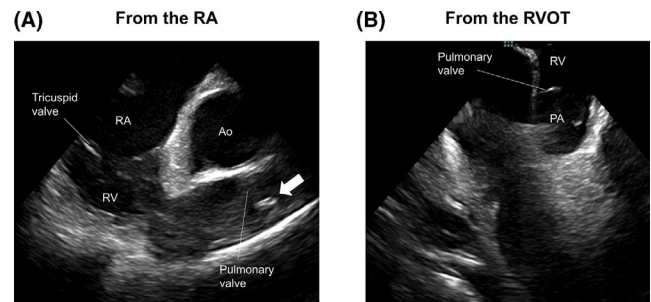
Pseudothrombotic appearance on pulmonary valve. A thrombus-like floating mass (11×6 mm) (white arrow) was detected by intracardiac echocardiography. RA, right atrium; RV, right ventricle
